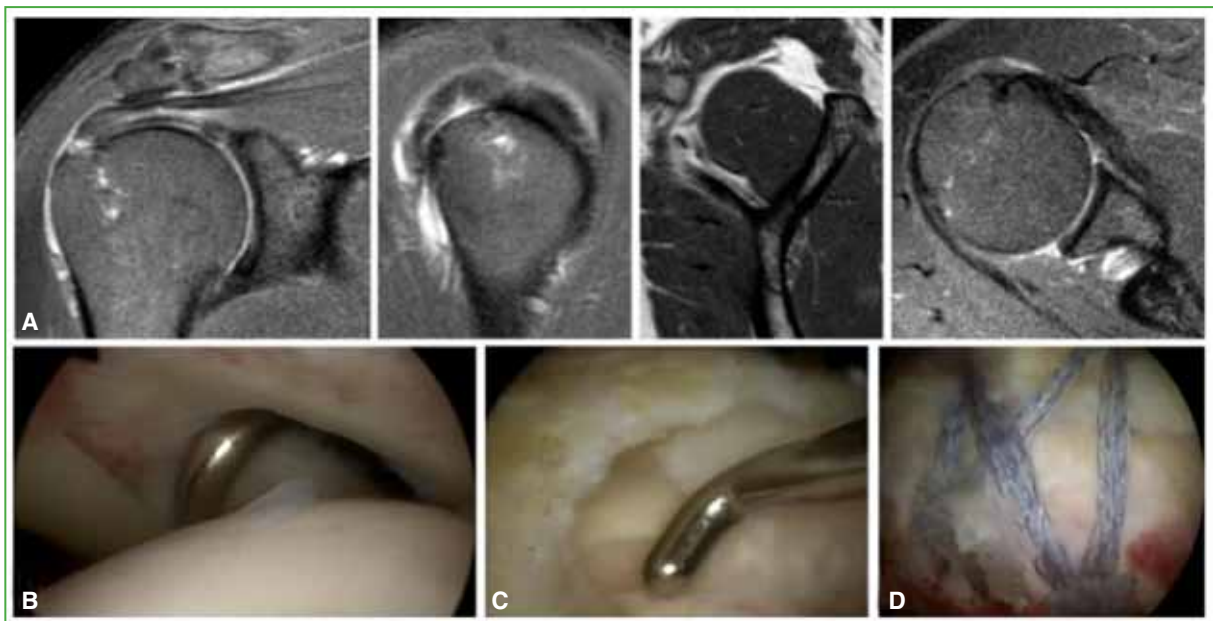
60-year-old patient with right supraspinatus injury. A. Magnetic resonance images. A complete insertional injury of the supraspinatus is observed. B. Intrarticular view of the injury. C. Subacromial view of the injury. D. Final subacromial view of the repair. Two medial and two lateral anchors were used.
